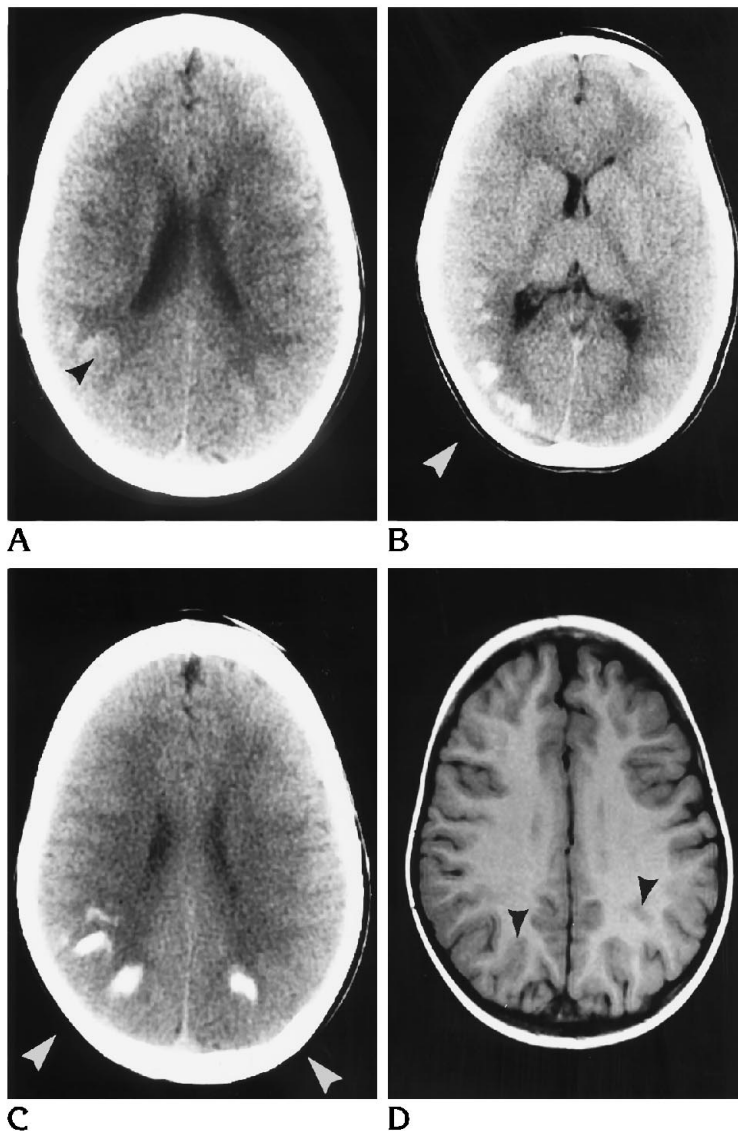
A, CT scan on initial presentation shows faint hyperdensity at the corticomedullary junction in the right parietal region (*arrowhead*).
